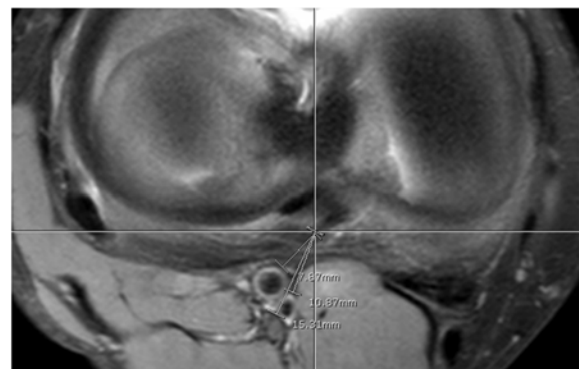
Axial MRI of the knee showing the shortest distance of the neurovascular structures to the PCL stump.
